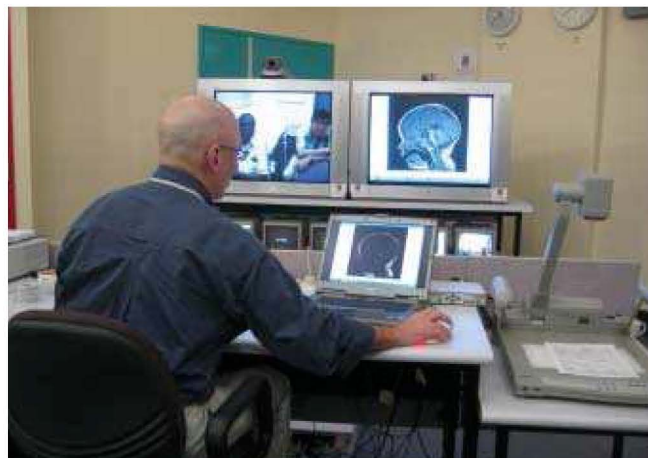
A paediatric neurologist discusses the results of an MRI scan during a telepaediatric consultation
